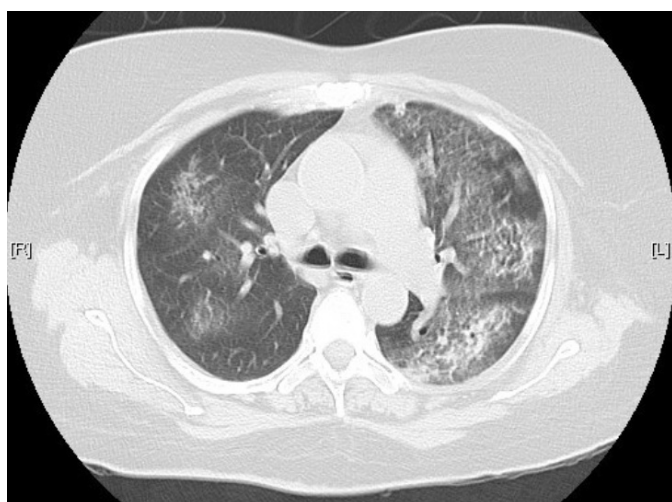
Computed tomography scan of the chest showing left lung ground glass opacity and interstitial thickening.
